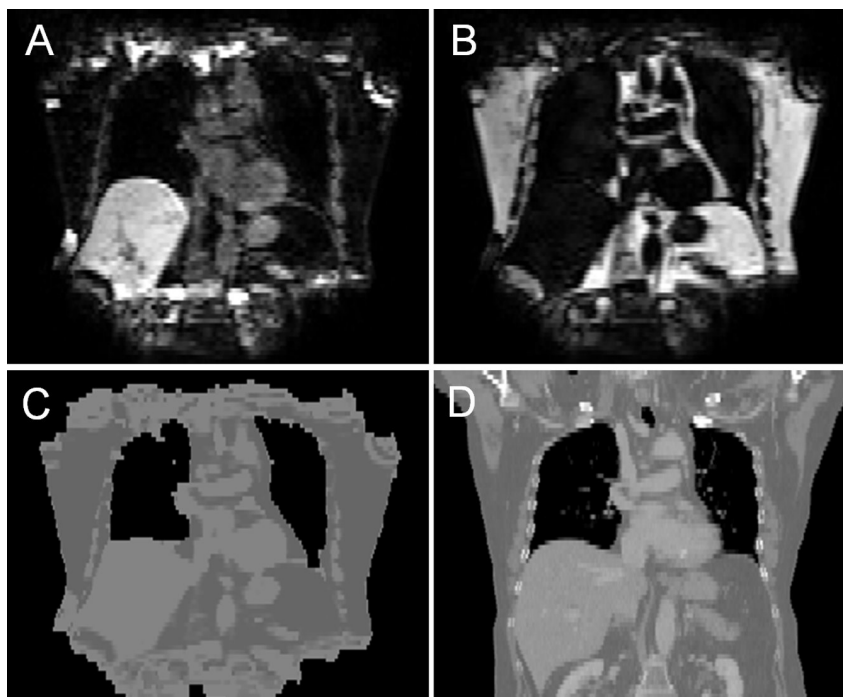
Segmentation of a VIBE Dixon sequence for attenuation correction purposes. The MRI water (A) and fat (B) images are combined and segmented to produce the MRI-based attenuation map (C). For comparison, CT-based attenuation map of the same patient (D).
